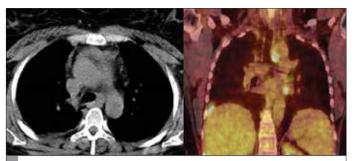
Thorax CT and PET-CT showing the left lower paratracheal lymph node (4L) of the patient, performed by EBUS-TBNA PET-CT: positron emission tomography-computerized tomography; EBUS-TBNA: endobronchial ultrasound-guided-transbronchial needle aspiration
